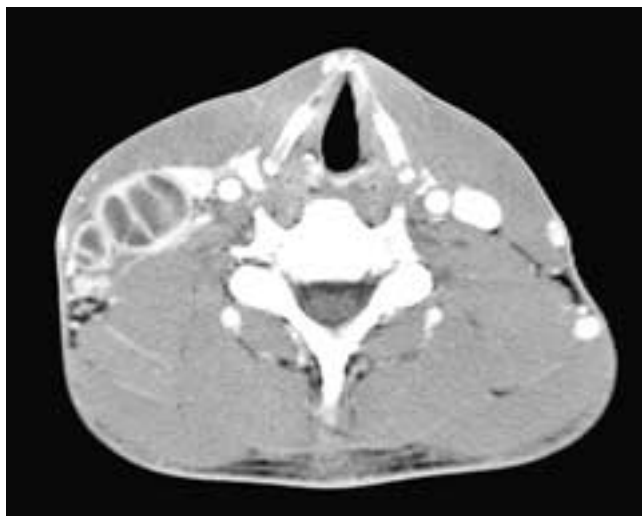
Axial contrast-enhanced CT scan shows several right partially necrotic, partially enhancing level III nodes. There is little effacement of adjacent fat planes in this patient with tuberculosis.
